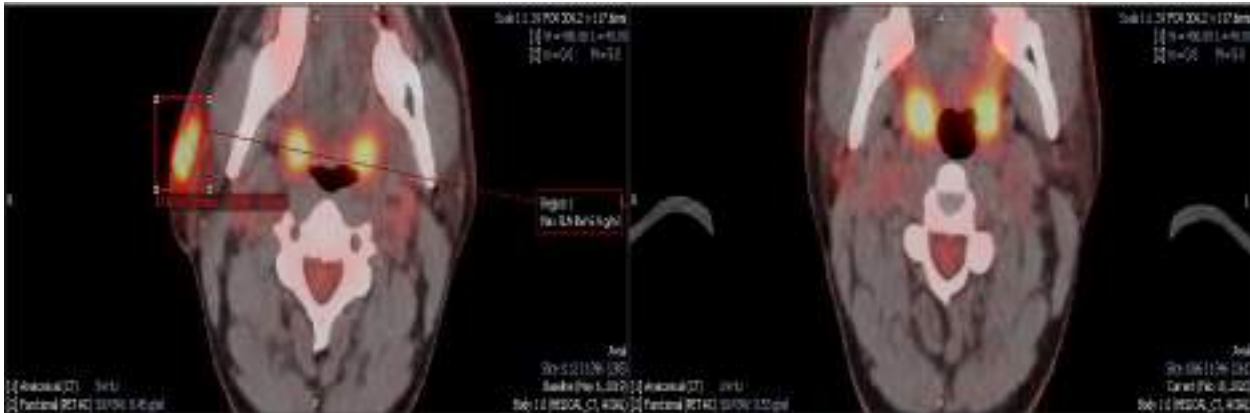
Comparison of preoperative and postoperative PET CT scan
